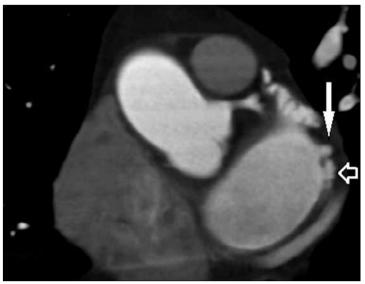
CT image demonstrates atrial diverticula (*long arrow*) and an accessory appendage (*short arrow*) in the same patient.
